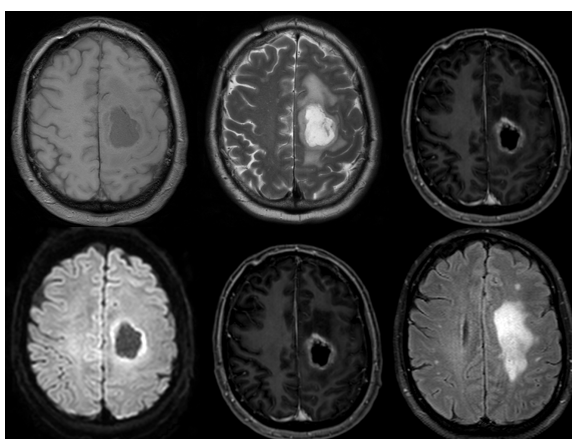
Brain MRI data. From top-left to bottom-right: T_1 -weighted MRI without contrast, T_2 -weighted MRI, T_1 -weighted MRI with contrast, FLAIR, DWI with sequence b -value of 0 mm/s^2 , DWI with sequence b -value of 1000 mm/s^2 .
